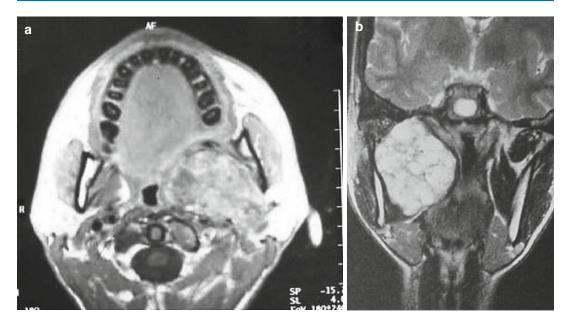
(a, b) Pleomorphic adenoma. Magnetic resonance imaging (MRI) showing extension to the parapharyngeal region of the tumor
